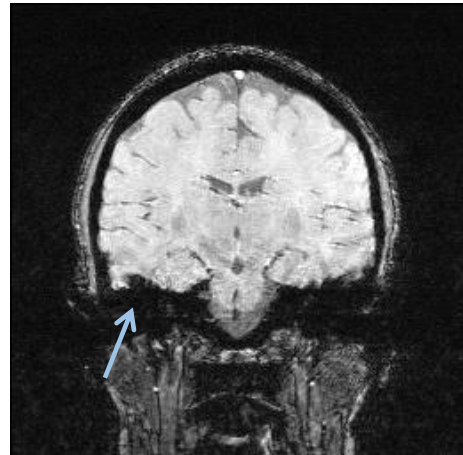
Signal loss and image distortion in a gradient echo MR image due to differences in susceptibility between air and tissue.
